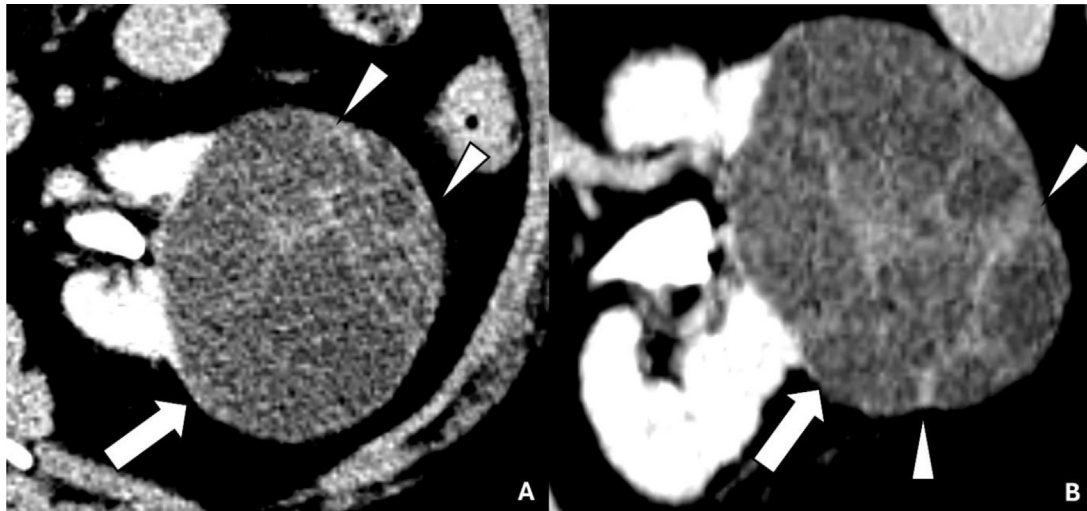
MEST in a 52-year-old with lower back pain. Axial (A) and coronal (B) contrast-enhanced CT images demonstrate a complex interpolar left cystic mass (arrows) with thick enhancing internal septa (arrowheads).
